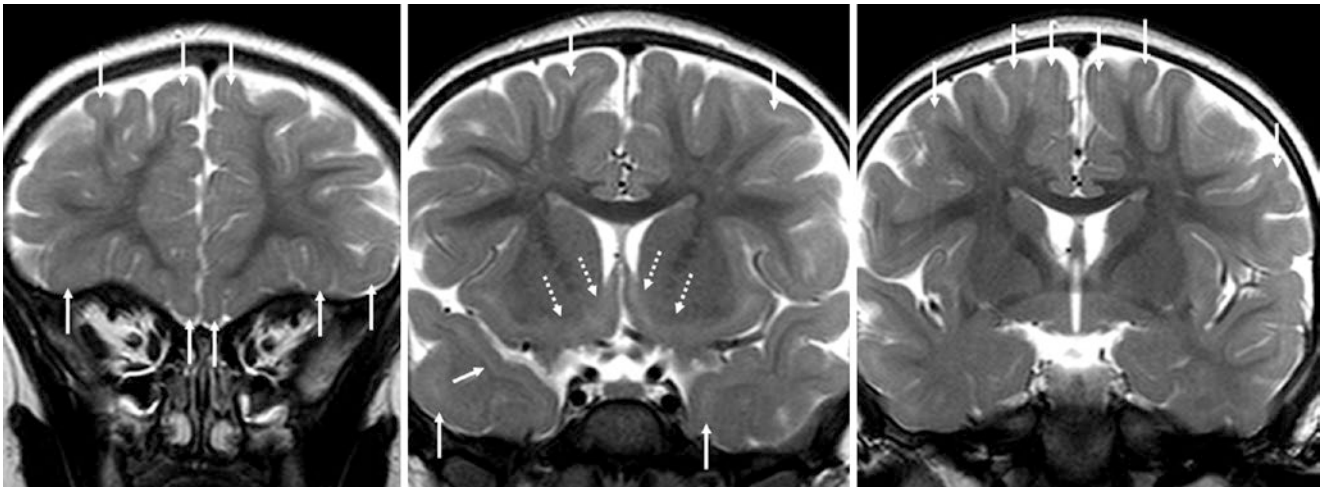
A 21-month-old with obesity had a normal 3T MRI. On coronal SE T2WIs, note residual, hyperintense “patchy” SCWM (*thin arrows*) within the anterior-inferior frontal WM, superior frontal gyrus anteriorly, and ATWM. Additionally, note residual bright signal
